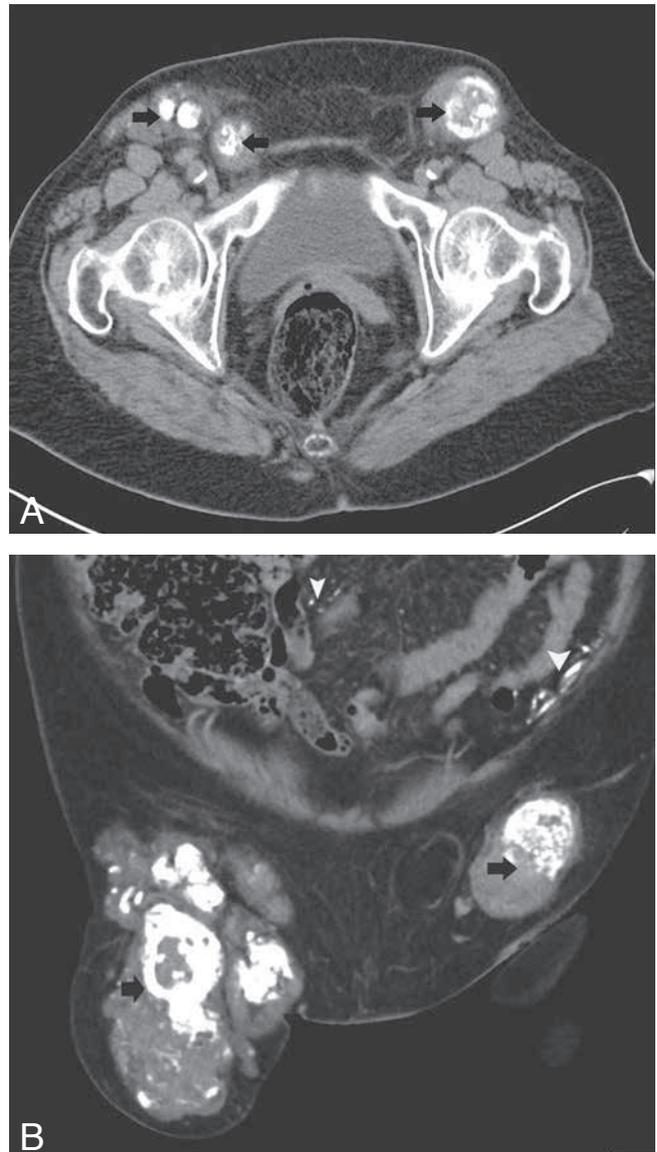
CT scan of the pelvis. Axial (A) and coronal reformatted image (B) shows bilateral massive inguinal adenopathy with intralesional coarse calcifications (black arrows). Note also small nodular calcifications within the omentum (white arrowheads).
